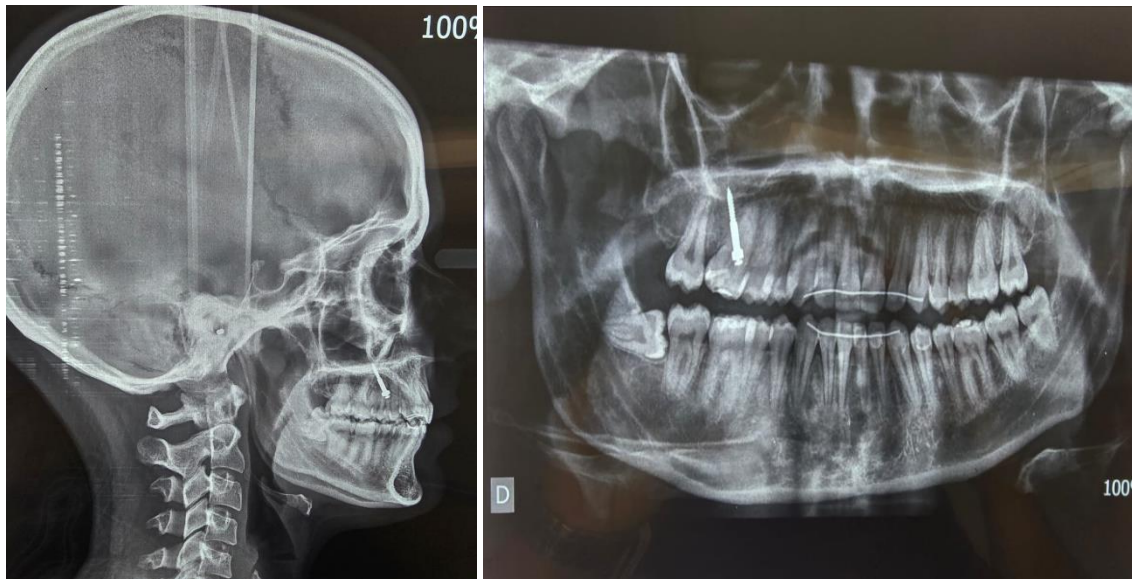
Post-treatment cephalometric radiograph
